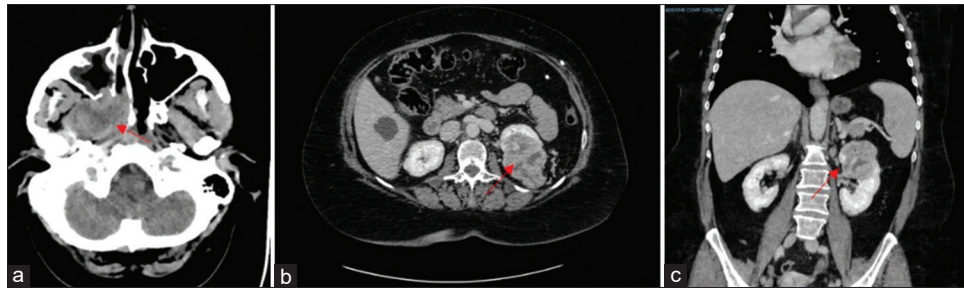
Skull base and abdomen contrast-enhanced CT scans. (a) Expansive process of the right pterygomaxillary fossa, extended to the right maxillary sinus and right sphenoidal sinus (red arrow). (b) Axial scans and left kidney superior pole mass (red arrow). (c) Coronal sections and left kidney superior pole tumour with renal vein thrombosis (red arrow). CT: Computed tomography
